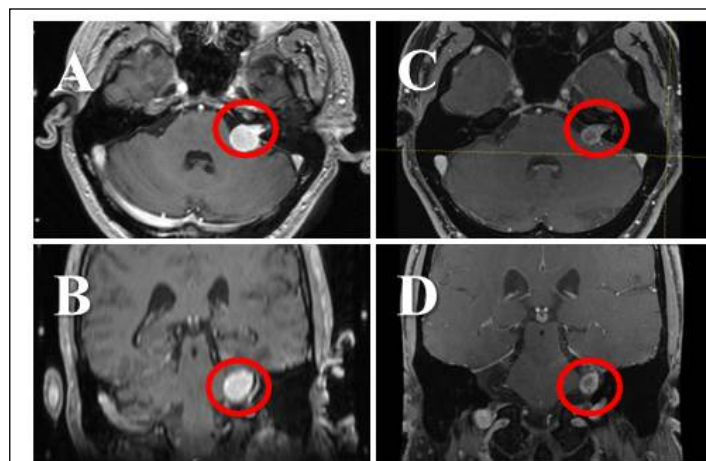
(A,B) Pre- and (C,D) post-HSRT T1-weighted gadolinium-enhanced MRI demonstrating left-sided VS with central necrosis and decreased contrast uptake suggestive of treatment effect.
